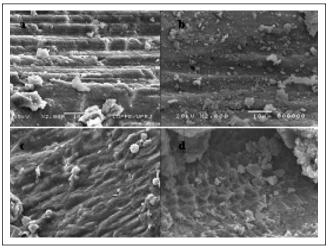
Internal aspect of the cavities showing presence of smear layer produced by high speed (2a and 2b) and ultrasonic abrasion systems (2c and 2d) in deciduous (2a and 2c) and permanent (2b and 2d) teeth (SEM – 2000X).
